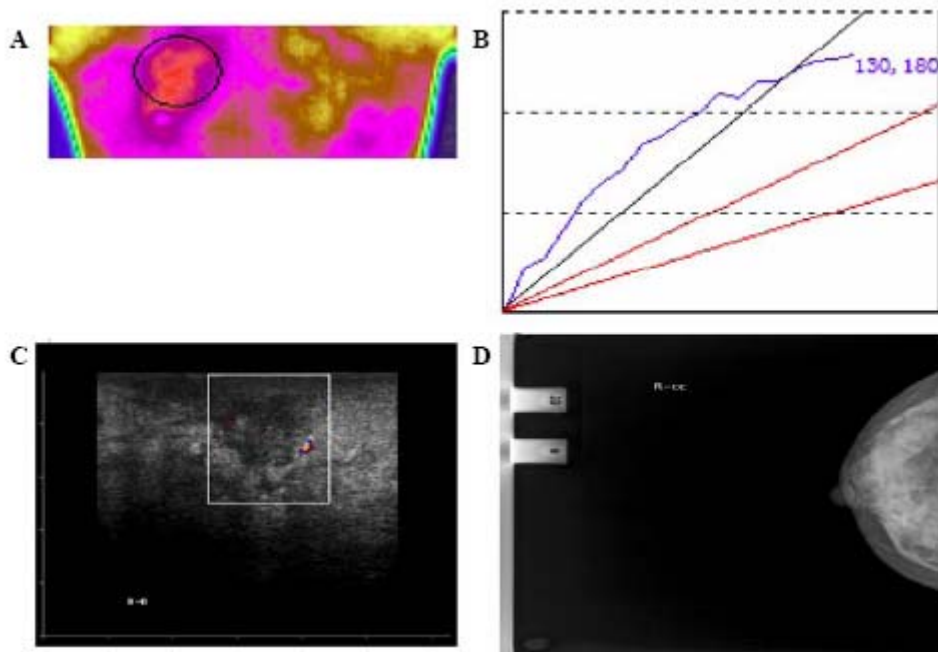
Case 3: granulomatous mastitis (A) Mammography showed depression of the right nipple and thickened skin. Enhanced gland density was observed at 10 o'clock. There was a mass-like image without a clear boundary, which suggested a malignant mass. (B) Color Doppler ultrasound showed a large uneven hypoechoic region in the right breast with obscure boundaries. Many blood flow signals were observed peripherally. (C) Far infrared thermography showed an increased temperature in the right breast that was significantly higher than that of the right breast, suggesting a lesion. (D) Thermal characteristic curve was consistent with inflammation; the final diagnosis proven by pathological examination was granulomatous mastitis.
